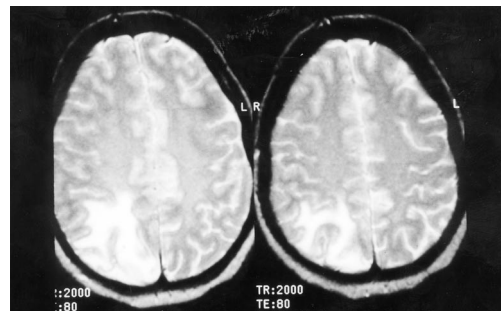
Magnetic resonance image of brain, showing Aspergillus in occipital lobe.
